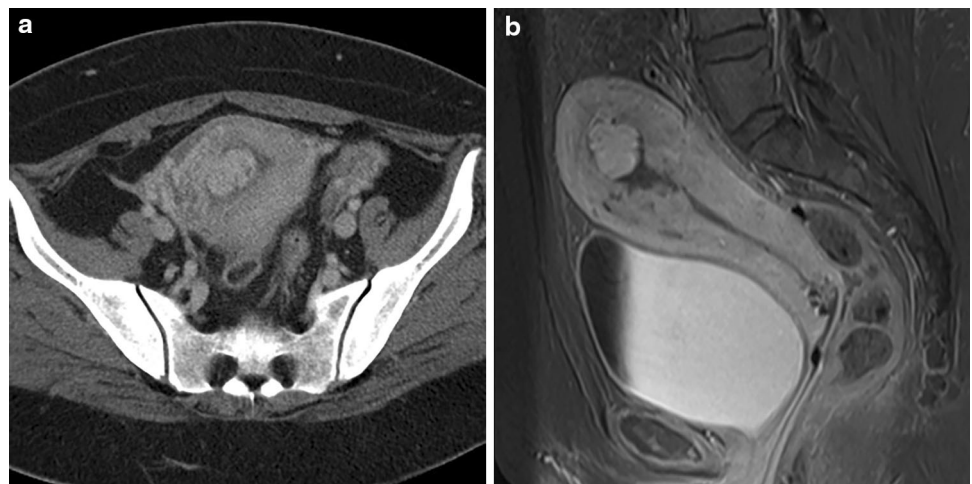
RPOC on CT and MRI. On axial CT (a) a complex-enhancing endometrial mass is noted. On sagittal T1WI post-contrast MRI (b), the endometrial mass is enhancing homogeneously
